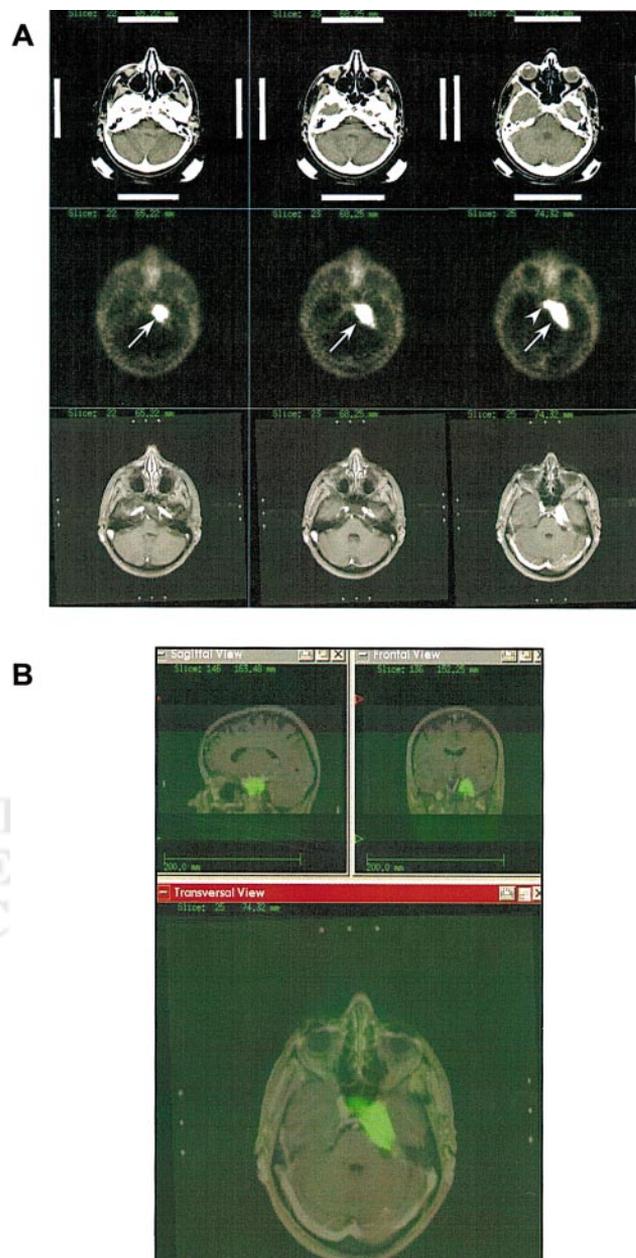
(A) Realigned CT, PET, and MRI scans of medial temporal/sphenoidal meningioma (arrow) beneath pituitary gland (arrowhead). (B) Image fusion of same patient (color coded, PET; black and white, MRI).
